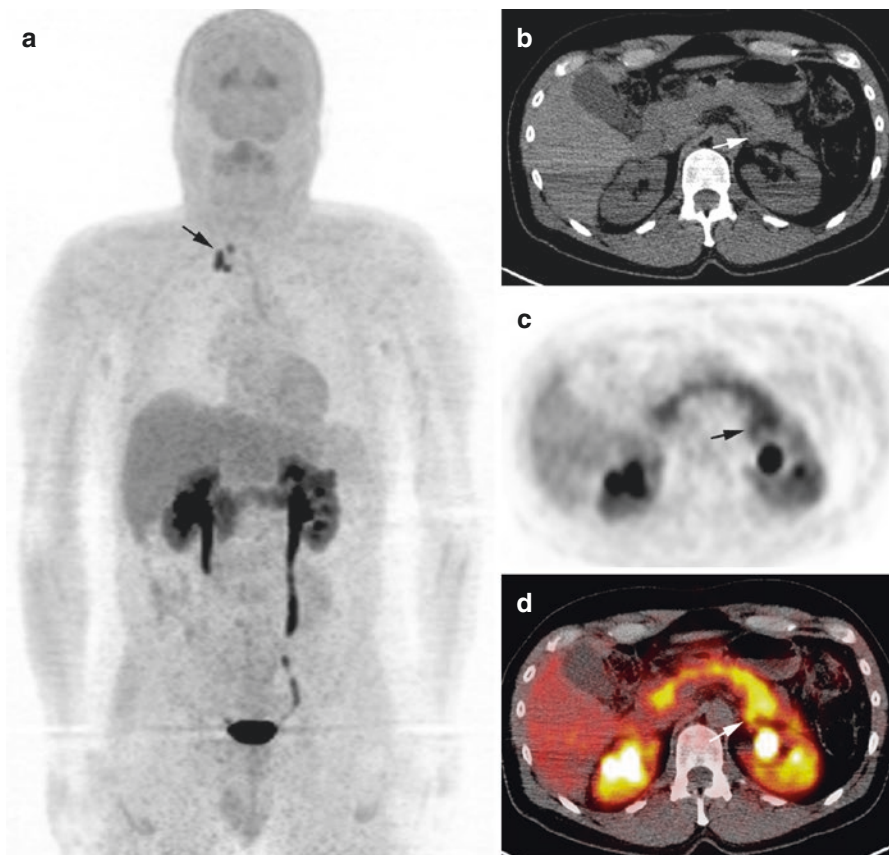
MEN2A with PHEO and persistent MTC. (a) ^{18}F -FDOPA PET/CT (MIP image) showing persistent cervical metastatic lymph nodes from MTC (arrow), (b) unenhanced CT showing a left adrenal nodule, and (c) axial ^{18}F -FDOPA PET and PET/CT are consistent with a small left PHEO (arrow)
